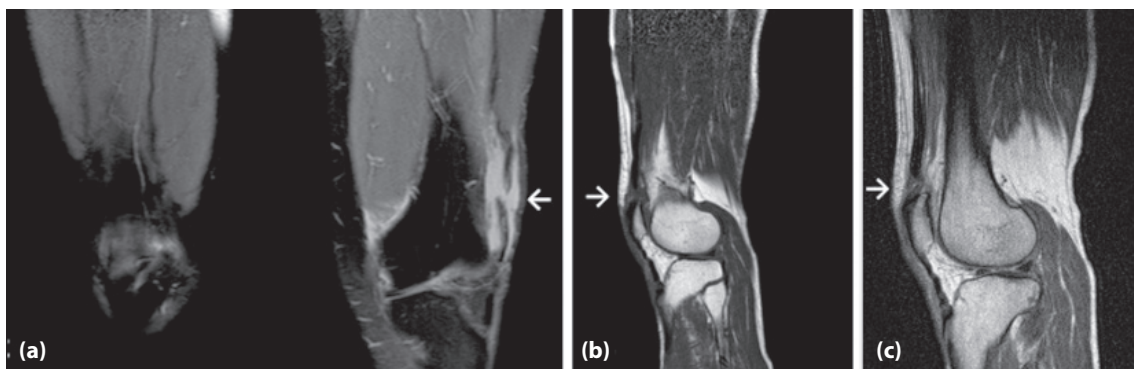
The rupture in musculotendinous junction of vastus lateralis is viewed in T2 fat-suppressed T2-weighted coronal MR image (a), and the view consistent with full-layer rupture in quadriceps tendon in T1-weighted (b) and in proton density-weighted sagittal images. (c) Fluid is present between tendon fragments.
